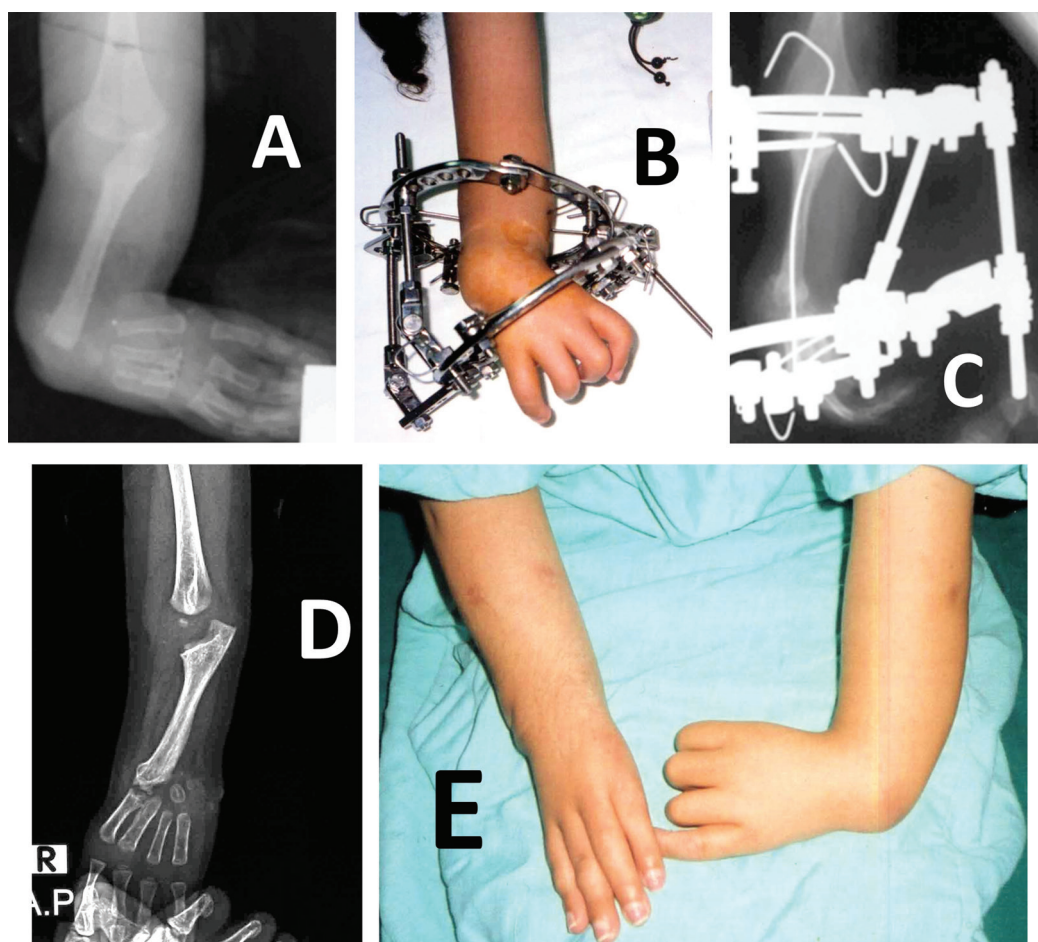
A case treated by centralization: A – preoperative radiograph; B – clinical photograph during correction; C – radiograph during correction by Ilizarov frame; D – follow-up radiograph at one year; E – clinical follow-up of the right side at one year
